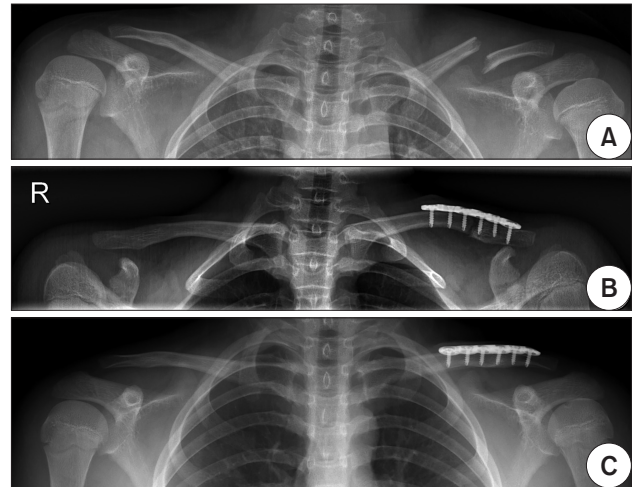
(A) Preoperative anteroposterior simple radiograph of a 12-year-old boy showing displacement of a midshaft fracture of the left clavicle. (B) Minimally invasive plate osteosynthesis was performed. (C) The radiograph at postoperative 13 months showed complete union.
